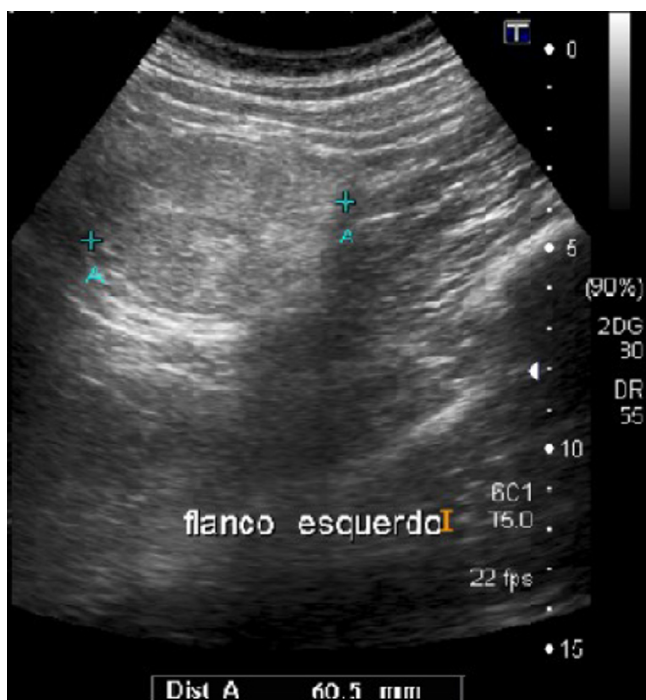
Ultrasonographic assesment showing heterogeneous mass in the left flank, with an diameter of 60,5 mm.
